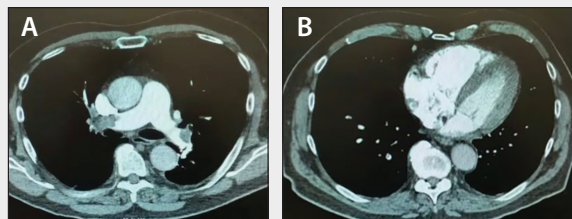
CT pulmonary angiogram showing subocclusive bilateral thrombus in the main PAs (A) and RV dilatation (B).
